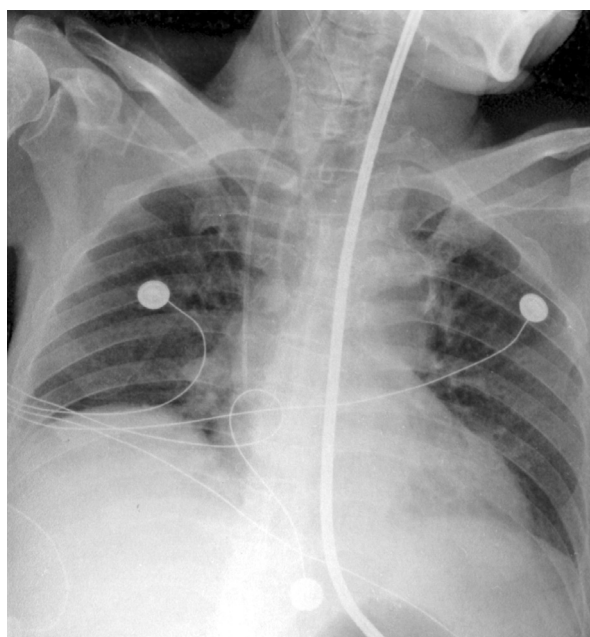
The supine chest radiograph after Sengstaken-Blakemore tube balloon tamponade, demonstrating bilateral clear lung fields
